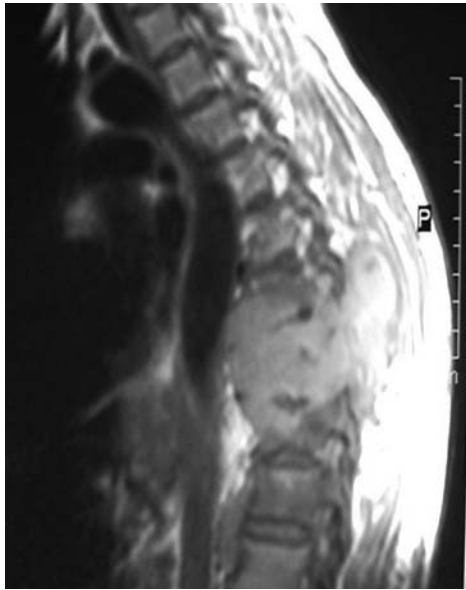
MRI of thoracic spine (T2 series) showing hyperintensity in the body of 8th, 9th and 10th thoracic vertebrae.
